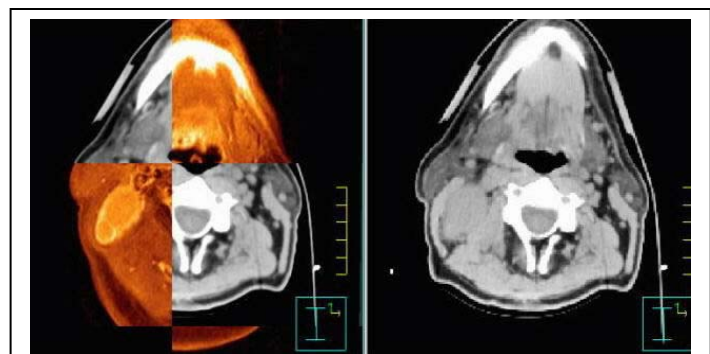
Image overlay of CT and MRI image
